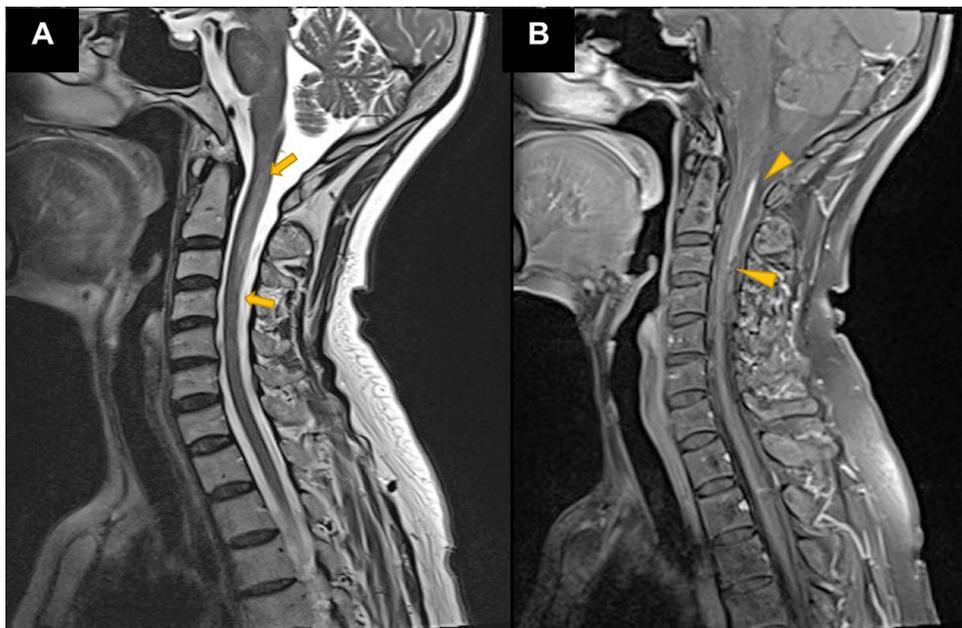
MRI of the cervical and upper thoracic spine obtained after the sixth attack, presenting recurrent myelitis. The T2-weighted sagittal scan (A) and its corresponding T1 post-contrast scan (B) showed a different location of T2 hyperintensity (arrows) and partial gadolinium enhancement (arrowheads). Thoracic myelitis involving T3–T5 was concurrent (MRI not shown).
